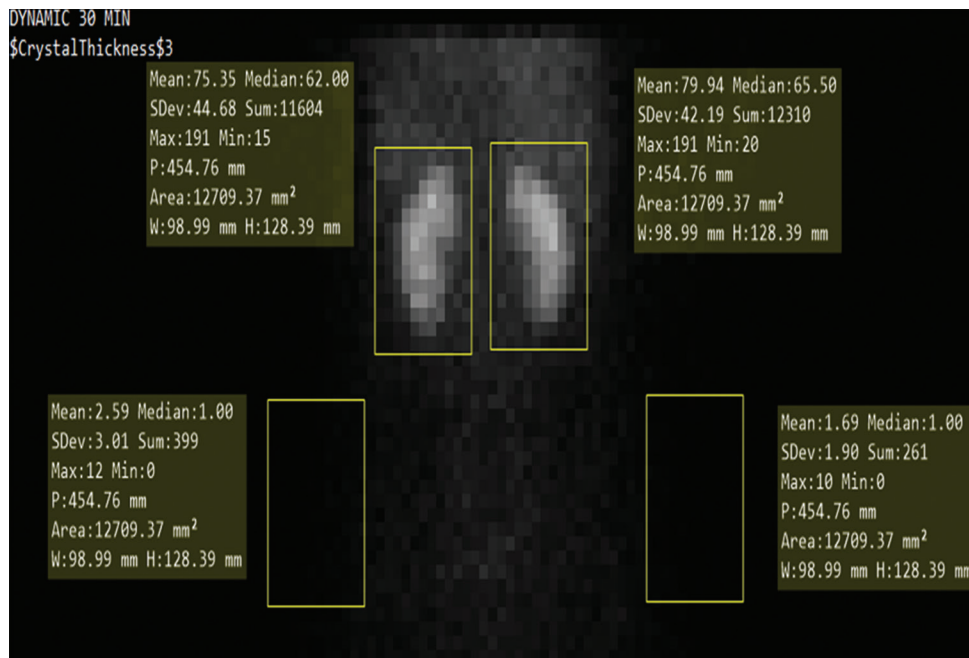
Regular rectangular region of interest selection method used in this study for delineating kidney regions and background areas in scintigraphic images. This method ensures consistency in kidney dimensions and coverage across all scintigraphic frames.
